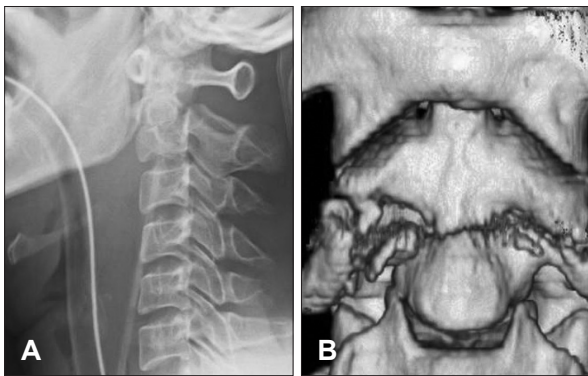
Lateral cervical radiograph revealing a type III dens fracture with slight anterolisthesis, angulation of dens, vertical displacement (A). A cervical spine computed tomography with 3D reconstructions revealing a type III dens fracture with extension into left facet joint, and separation between the fragments of axis (B).
